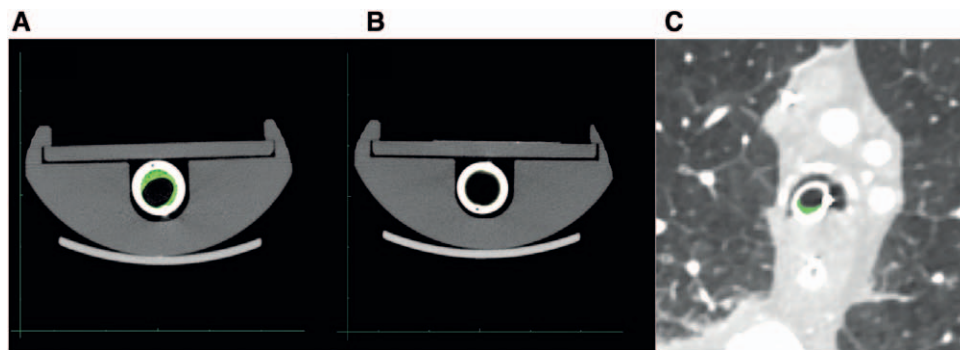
High-resolution computed tomography (HRCT) and clinical chest computer tomography scan images: (A) HRCT of a tracheal tube (TT) recently removed from a patient showing a reduction of TT internal cross sectional area due to mucus collection (in green); (B) HRCT of a new TT; (C) clinical chest computer tomography image performed on an intubated and mechanically ventilated patient: secretions (in green) layer dependently within the TT lumen.
